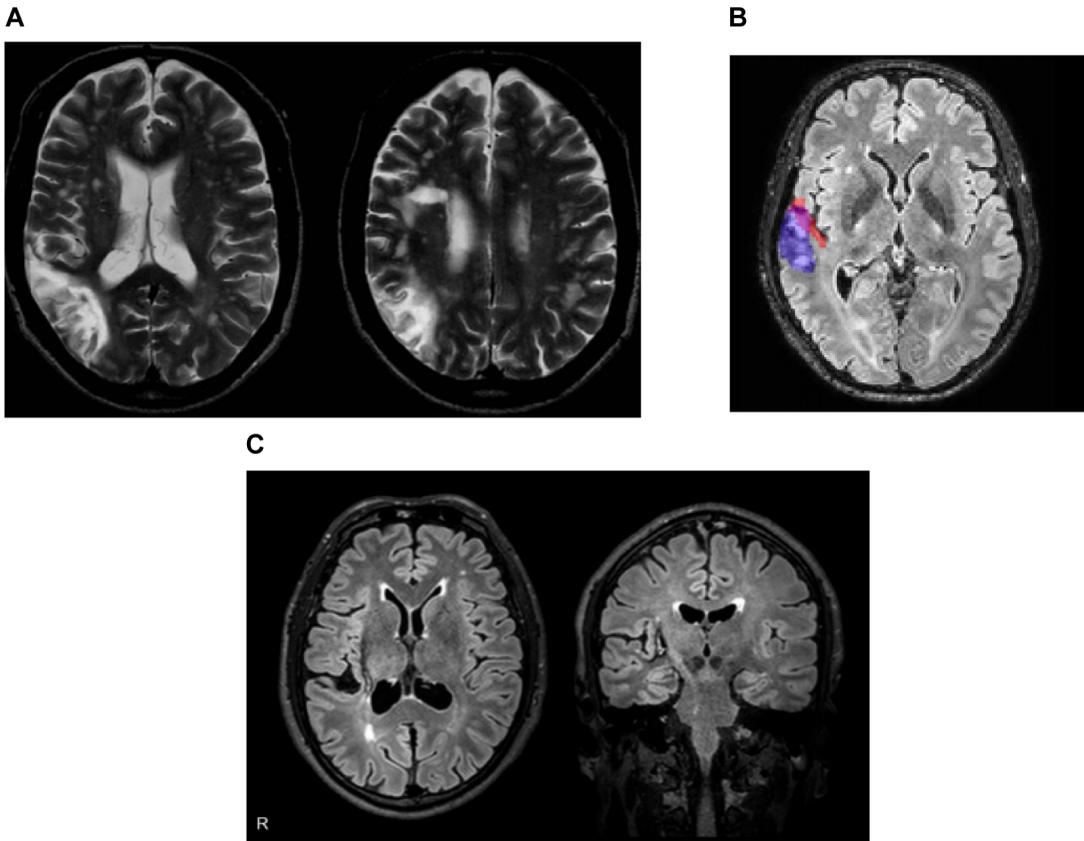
Lesion locations from three previously published cases of acquired musical anhedonia. All reproduced with permission of the publishers. (A) T2-weighted MRI depicting a lesion to the RH inferior parietal lobule. Reproduced from Satoh *et al.*⁴⁶ with permission from the publisher (Taylor & Francis Ltd). (B) FLAIR-sequence MRI depicting a lesion to the RH superior temporal gyrus (depicted in purple, Heschl's gyrus is depicted in pink). Reproduced from Hirel *et al.*⁶² (C) FLAIR-sequence MRI depicting a lesion to the RH putamen. All images in radiological convention (right hemisphere on the left side of the page). Reproduced from Satoh *et al.*⁵² with permission from the publisher (Taylor & Francis Ltd).
